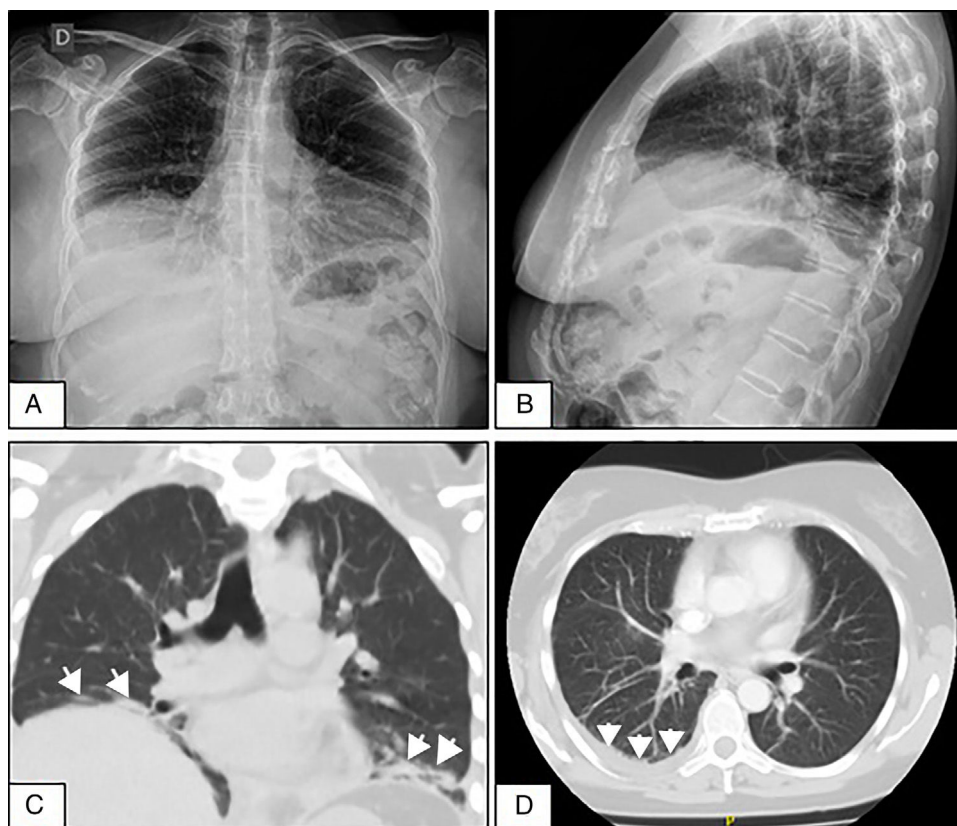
(A and B) Front and side-view chest X-rays showing the elevation of both hemidiaphragms and bibasilar laminar atelectasis. (C) Coronal CT without contrast material showing diaphragmatic elevation and subsegmental atelectasis (arrows) in both lung bases. (D) Axial CT of the chest with contrast material showing slight pleural effusion in the right lung base (arrows).
